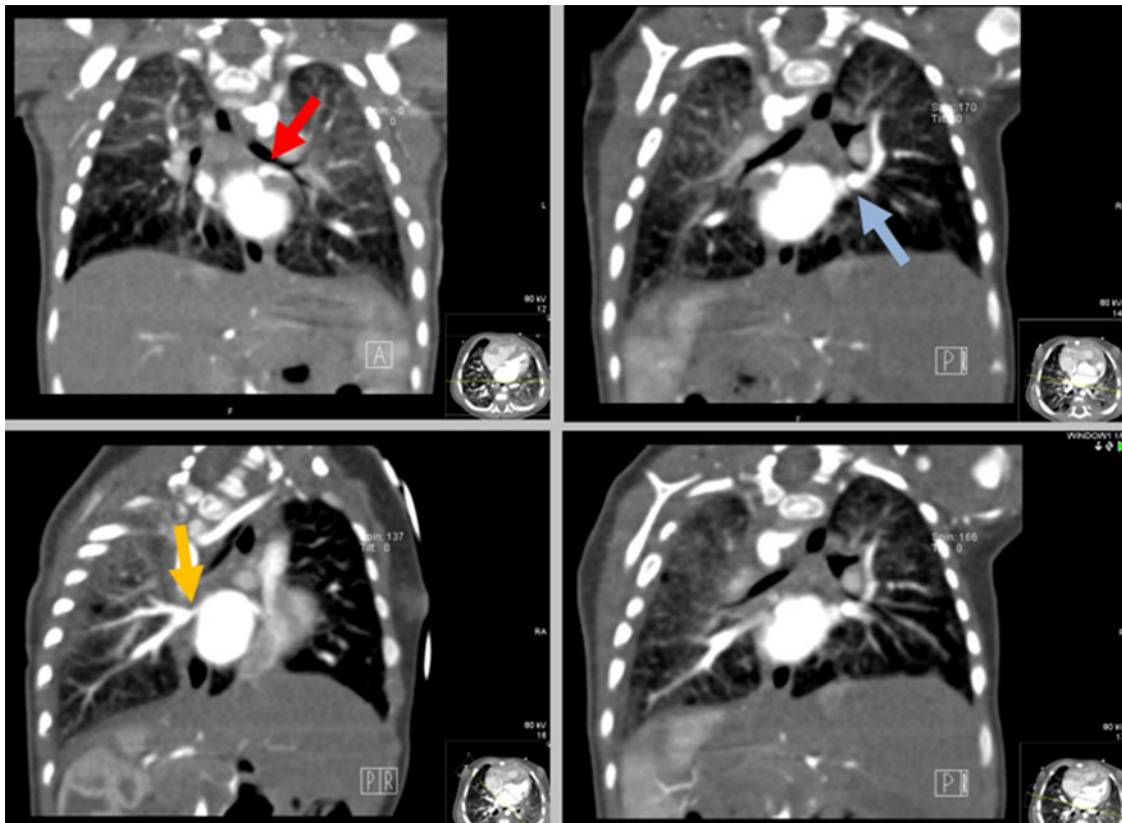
Cardiac angiogram CT showing stenosis of all the pulmonary veins (red arrow – left inferior pulmonary vein; blue arrow – left superior pulmonary vein; yellow arrow – right common trunk). CT: computed tomography.
